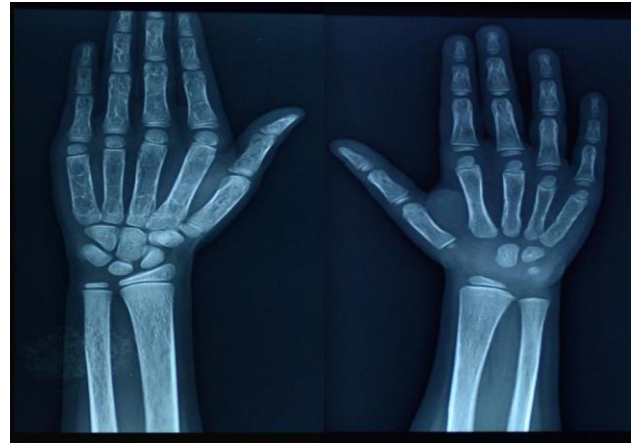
X-ray wrist showing coarsened trabeculae, thinned out cortex, loss of density and diffuse osteoporotic changes in a thalassemic child.
